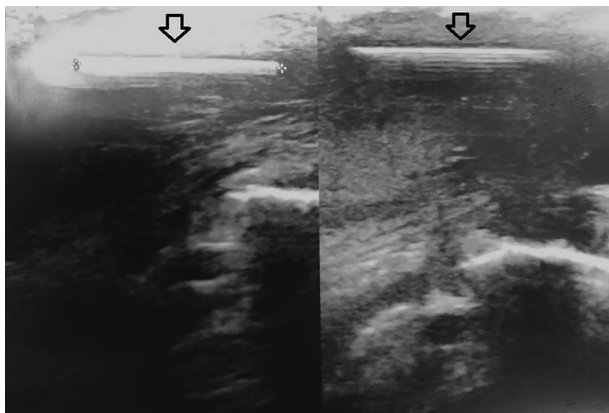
Sonographic findings of an hyperechoic line without posterior shadow (black arrow) in the longitudinal scan of the right testis, measuring 1.82 cm in length, at the external lateral side of the testis.
